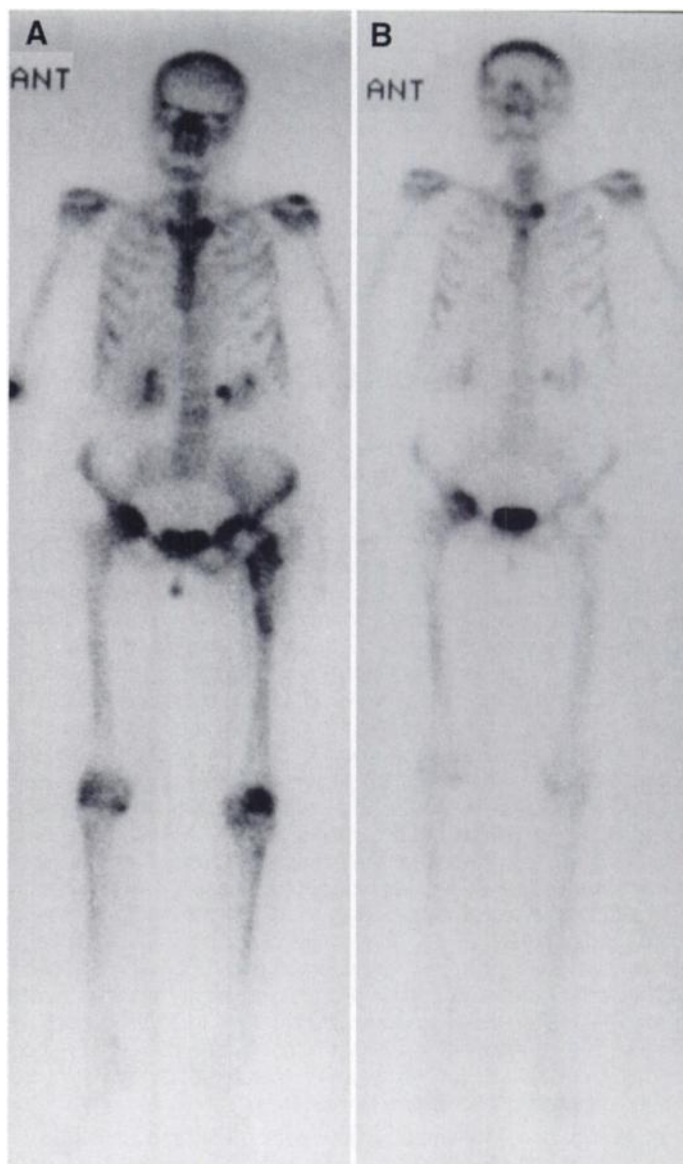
(A) Nonmalignant hot spots in 60-yr-old woman with hyper-nephroma show increased tracer uptake in left shoulder and manubriosternal joint. (B) No scintigraphic changes 10 mo later confirmed degenerative disease. Tracer uptake in hips and right femur was due to orthopedic surgery.
